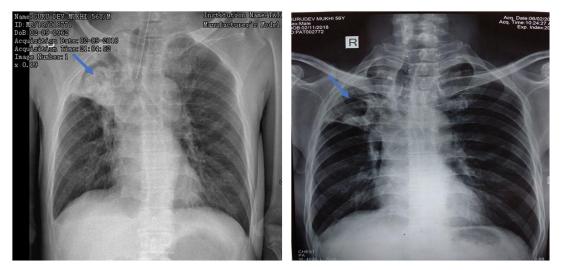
Comparative chest radiograph after 6 months. Image on the right shows clearing of the opacity within the cavity (shown by arrows)
